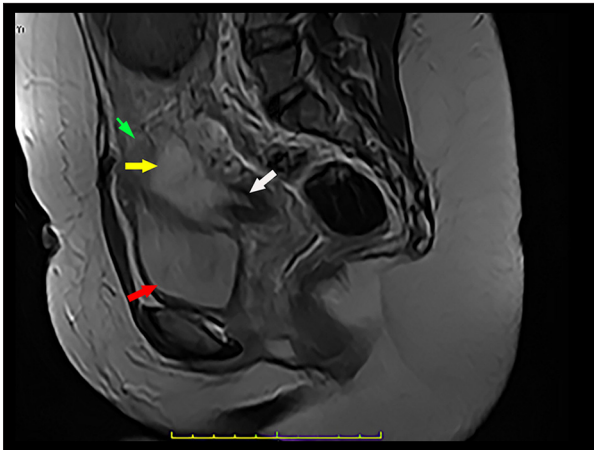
Sagittal T2 weighted magnetic resonance image through the pelvis. The posterior aspect of the gestational sac (yellow arrow) extends into the endometrial cavity of the lower uterine segment (white arrow). Urinary bladder (UB) (red arrow); upper uterine segment (green arrow).
